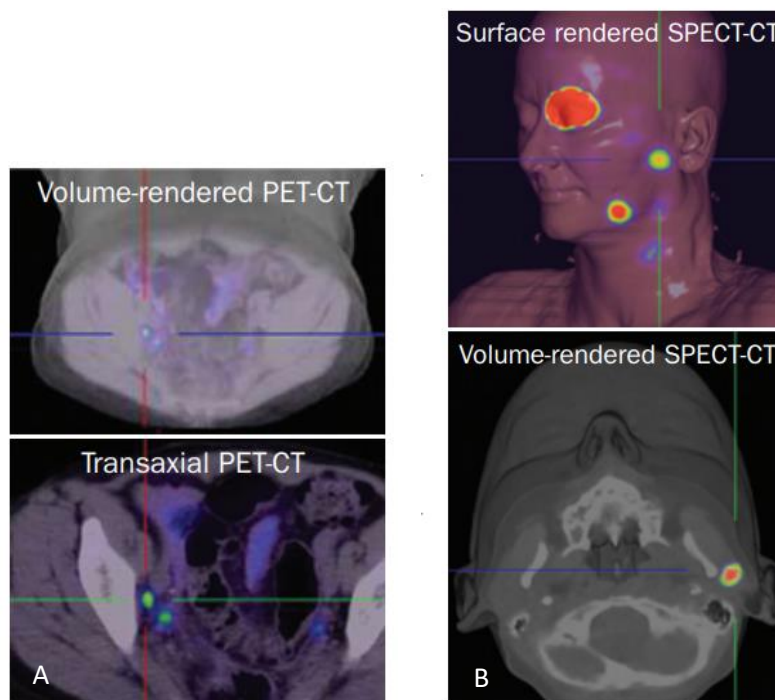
A) A PET-CT scan for ^{18}F -FDG for the detection of small malignant melanoma metastases B) A SPECT-CT scan of $^{99\text{m}}\text{Tc}$ -colloid for sentinel lymph-node detection. ²⁵
